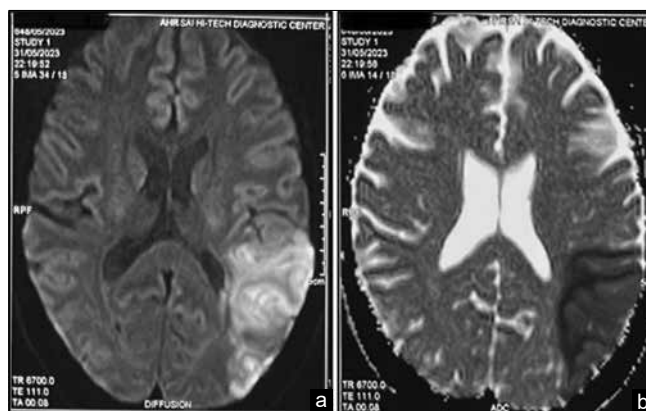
(a) Magnetic resonance imaging showing diffusion restriction in inferior division of M2 of left middle cerebral artery, (b) Apparent diffusion coefficient sequence confirms acute infarct in same area
